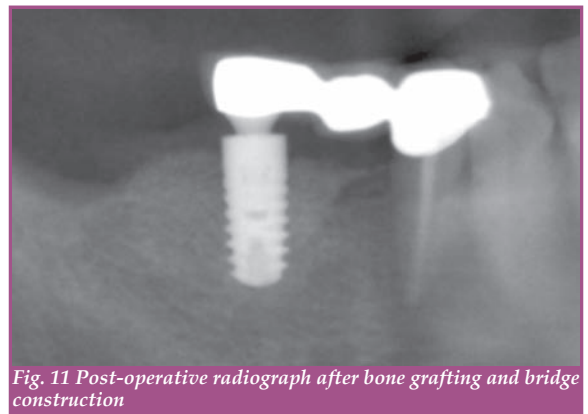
Post-operative radiograph after bone grafting and bridge construction
